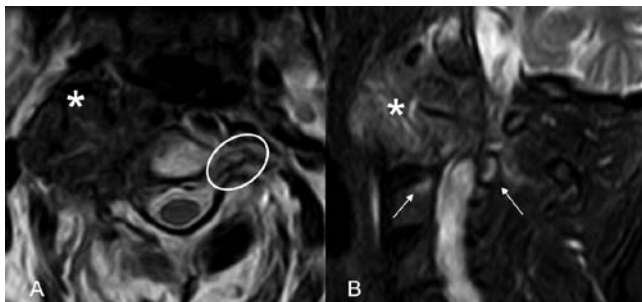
MRI sequences. (A) T2W DRIVE (Philips) on axial plane and (B) T2W FSE on sagittal plane. The bulky laterocervical mass (asterisk) shows a homogeneous hypointensity on T2W images. (A) T2W 3D DRIVE helped to assess the root-nerve compression in the conjugation foramen; the left is completely normal (white oval). (B) T2W highlights the bone edema on C3 vertebral superior endplate and on C2 posterior spinous process (white arrows). FSE: fast spin echo; T2W: T2-weighted.
